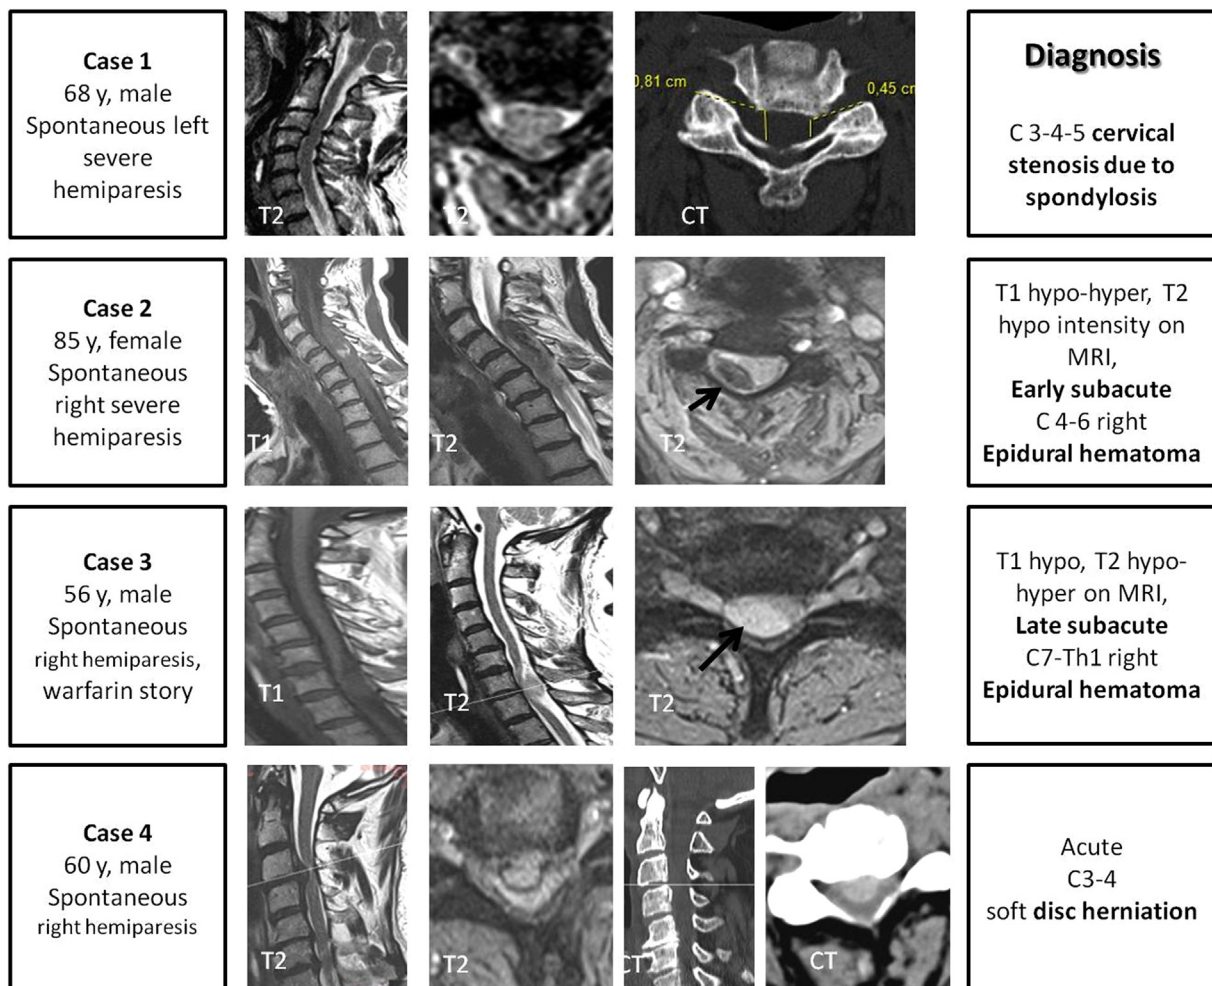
(Parts 1 and 2). Clinical and radiographic characteristics of all 8 cases.
